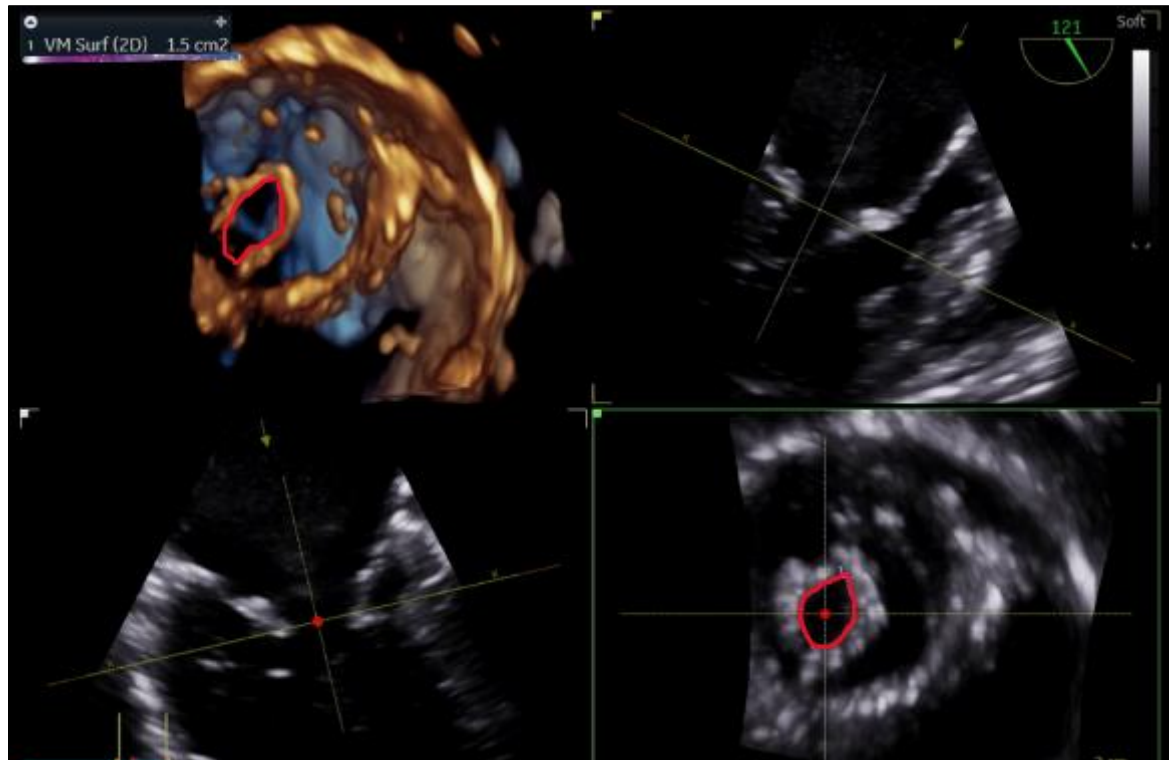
3D planimetry of the mitral valve (SVM=1.5cm²) using transoesophageal echocardiography (TEE)
